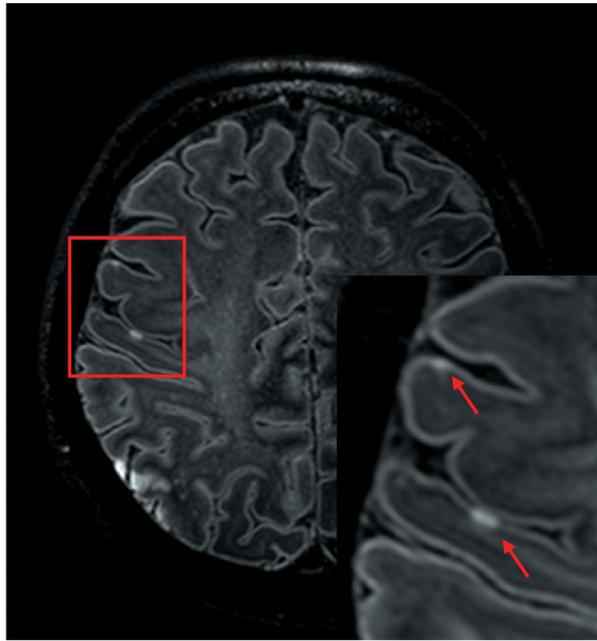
Example of cortical ischemic lesions on MR images obtained at 7Tesla. FLAIR images from a 57 year old woman with a history of atrial fibrillation who presented with aphasia and left-sided hemiparesis based on cortical ischemia in the right middle cerebral artery territory. Note the small cortical hyperintensities (arrows), which represent minute acute ischemic lesions.
